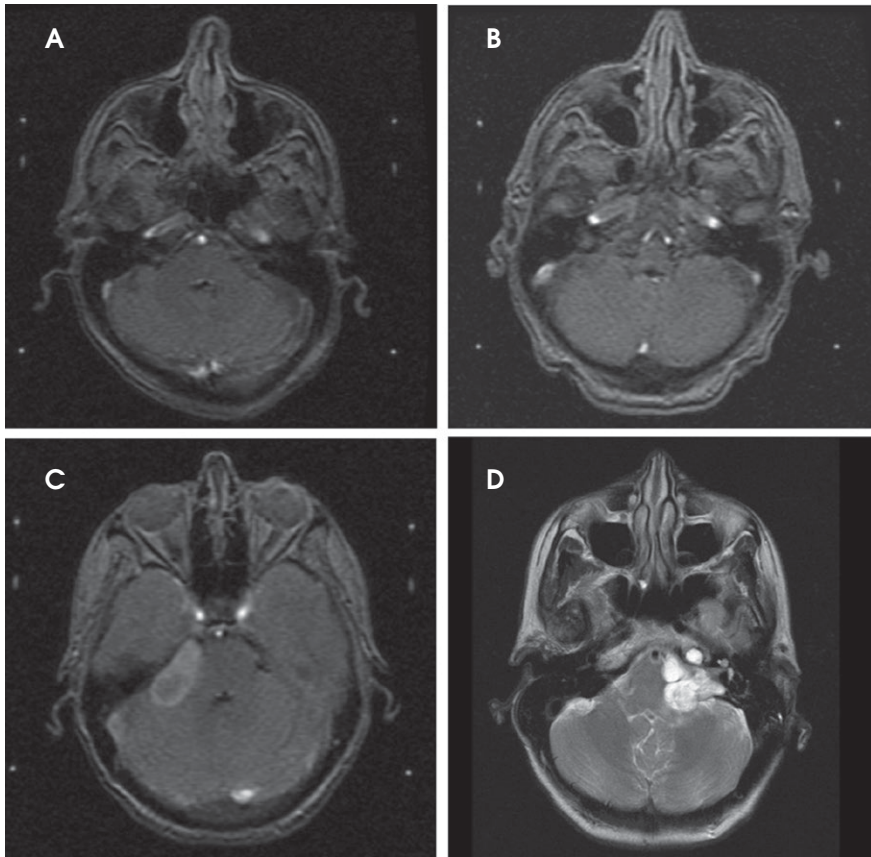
T2-weighted MRI with contrast enhancement showing the 4 stages of AN growth (A-D): (A) Intracanalicular right-sided AN; (B) Cisternal (filling the cerebellopontine angle) right-sided AN; (C) Brainstem compressive right-sided AN; and (D) Hydrocephalic (involving ventricular deviation) left-sided AN
